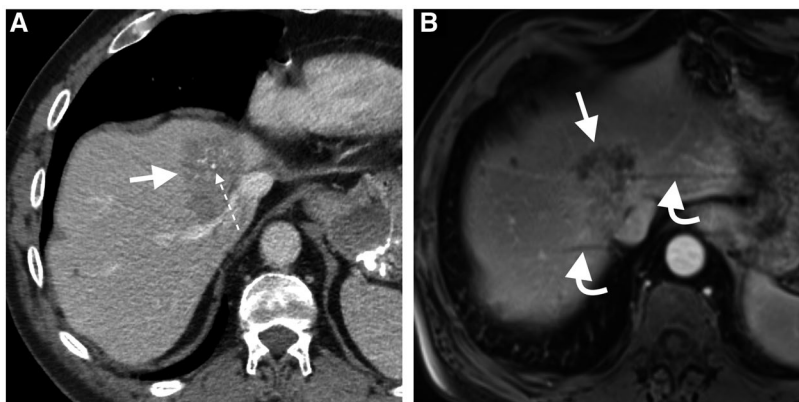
A 65-year-old woman with hepatic metastasis from mucinous colorectal cancer. Central calcification (dotted arrow) within a hypoattenuating liver mass is seen only on portal venous phase CT image (A). The mass is heterogeneous hypoenhancing on the axial dynamic postcontrast portal venous-phase MRI (B), but calcification is not seen. Also, note the respiratory motion artifacts on MRI (curved arrows), a recognized limitation of MRI in the assessment of liver lesion close to the hepatic dome.
